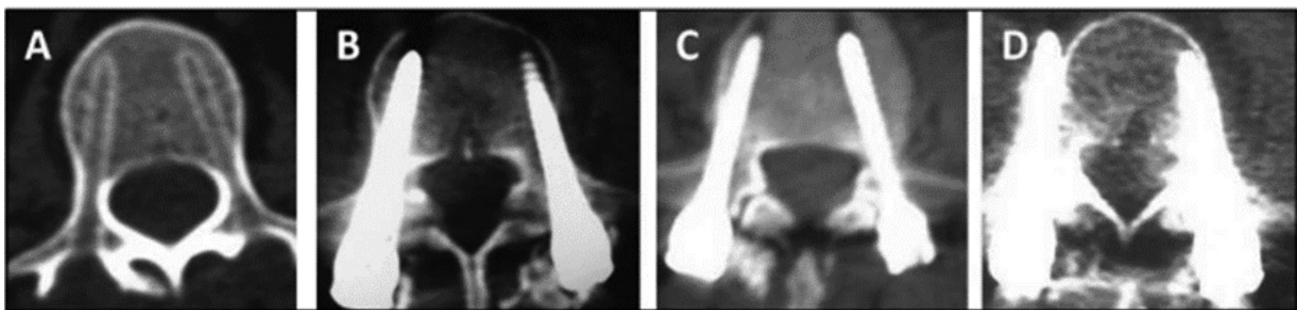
(A) Axial computed tomography image showing the pedicle screw is completely contained within the pedicle, (B) ≤ 2 mm perforation of the lateral wall of the right pedicle, (C) 2.1 to 4 mm perforation of the lateral wall of the right pedicle, (D) > 4 mm perforation of the lateral wall of the right pedicle.¹
